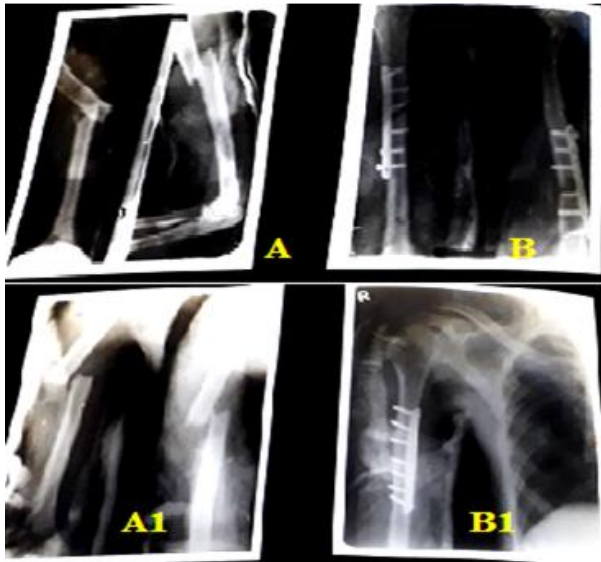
Radiographs: A, A1- pre-operative, B, B1- post-operative
